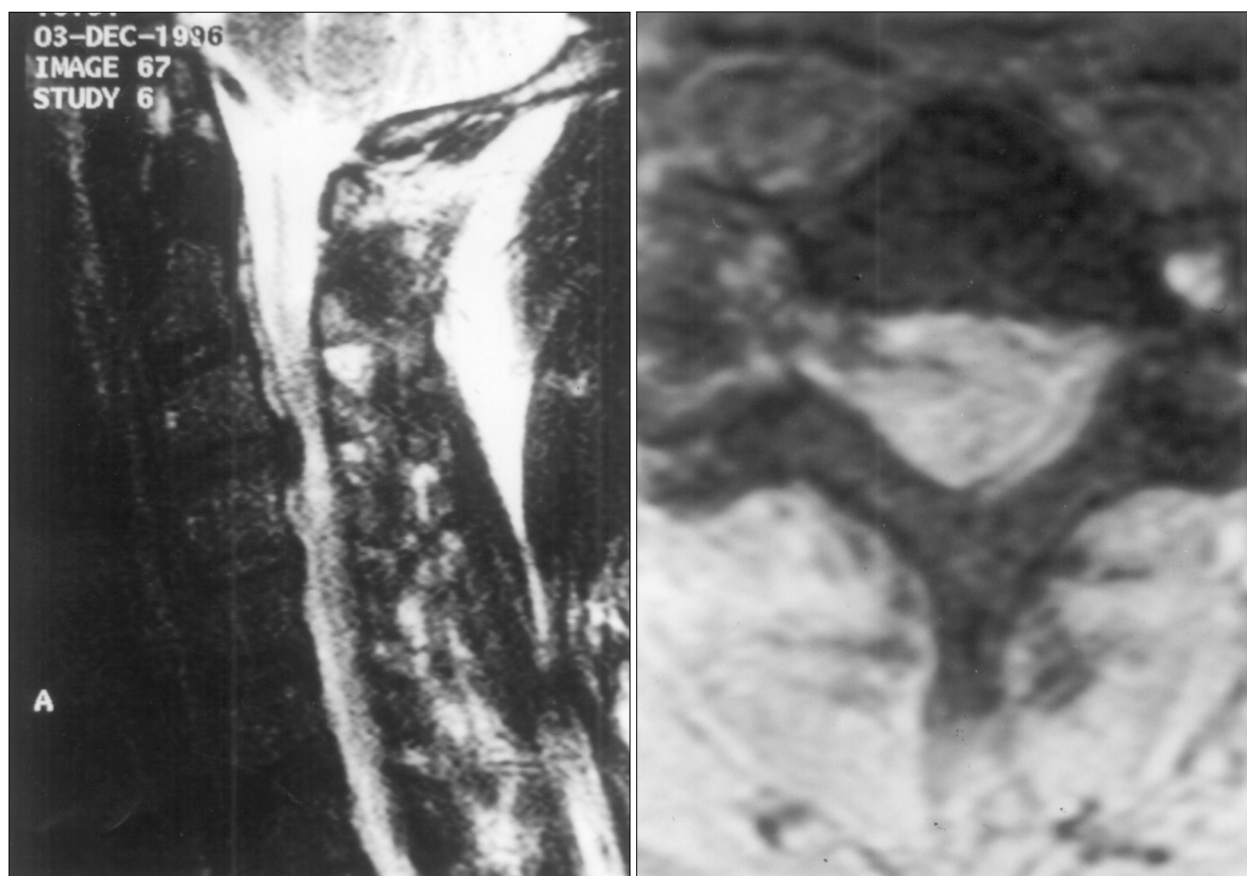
Magnetic resonance images obtained in a 30-year-old man with normal vertebral alignment and Frankel grade A weakness after motor vehicle accident(case 1). Preoperative MR sagittal(left) and axial(right) images show spinal cord compression by ruptured disc. Intramedullary signal intensity is high in T2-wighted image. The patient did not improve after operation.
